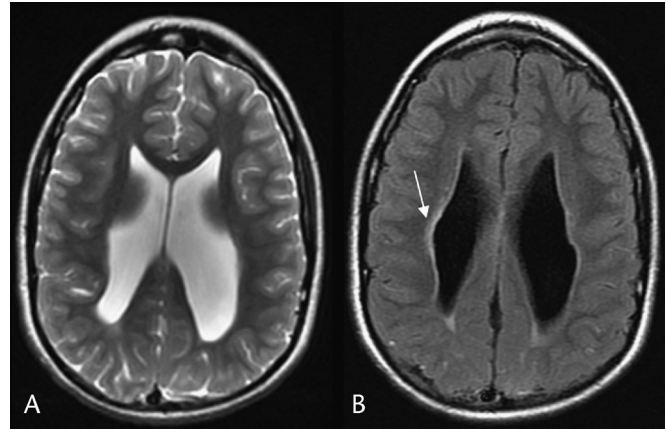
Periventricular leukomalacia. Axial T2 (A) and axial FLAIR (B) images show lateral ventriculomegaly with irregular margins, periventricular high intensities (white arrow), and decreased white matter volume.
